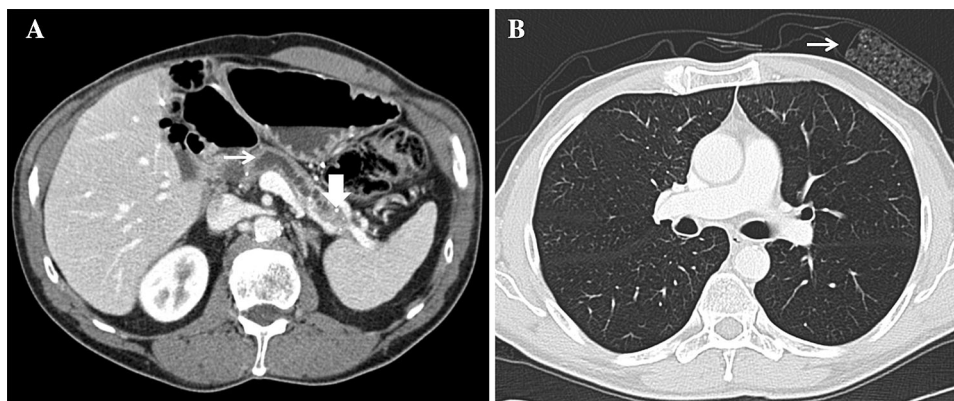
62-year-old man with history of chronic pancreatitis. CT showing pancreatic calcifications (A thick arrow), dilated main duct (A thin arrow), and a pack of cigarettes (B thin arrow) in his breast pocket indicative of association of smoking with chronic pancreatitis.
